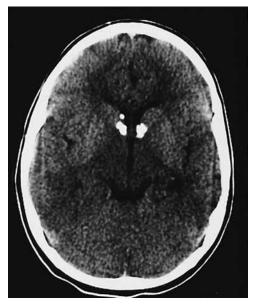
Tuberous sclerosis. This computed tomography (CT) cut through the foramina of Monro shows the multiple periventricular calcific deposits characteristic of this disorder. (*Courtesy Division of Neuroradiology, University Health Center of Pittsburgh, Pittsburgh, Pa.*)
